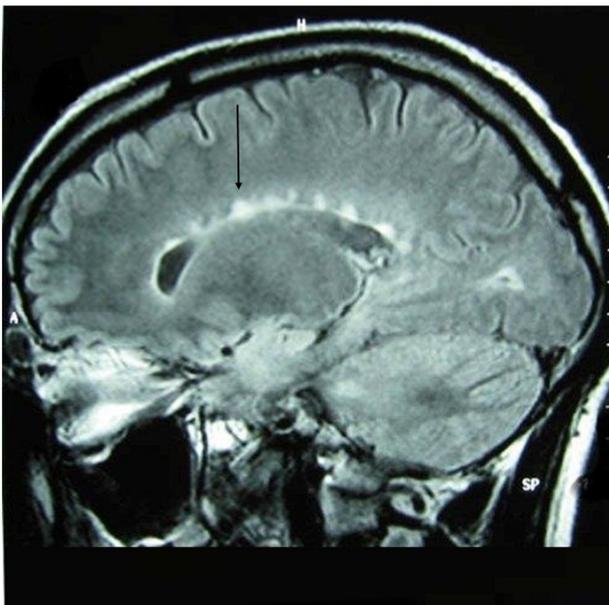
Brain MRI, parasagittal view shows plaques in periventricular area.
